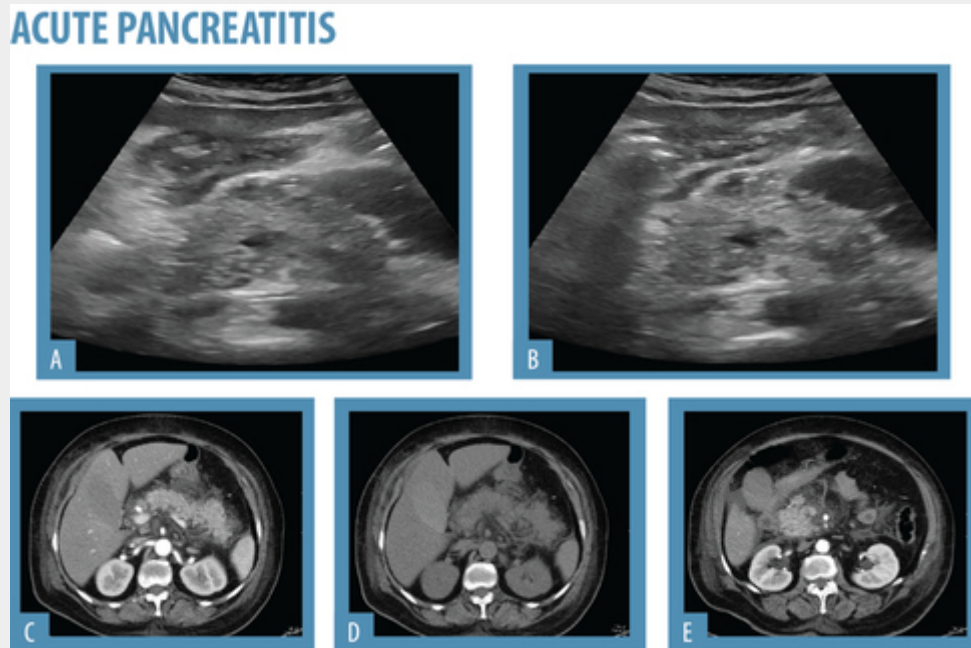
A) and B) are US images of the pancreas. There is marked enlargement of the pancreatic gland and irregular contours. The patient underwent CT (C,D and E) which corroborates the US findings. There is marked pancreatic enlargement and fat densification, but no collections are apparent.
